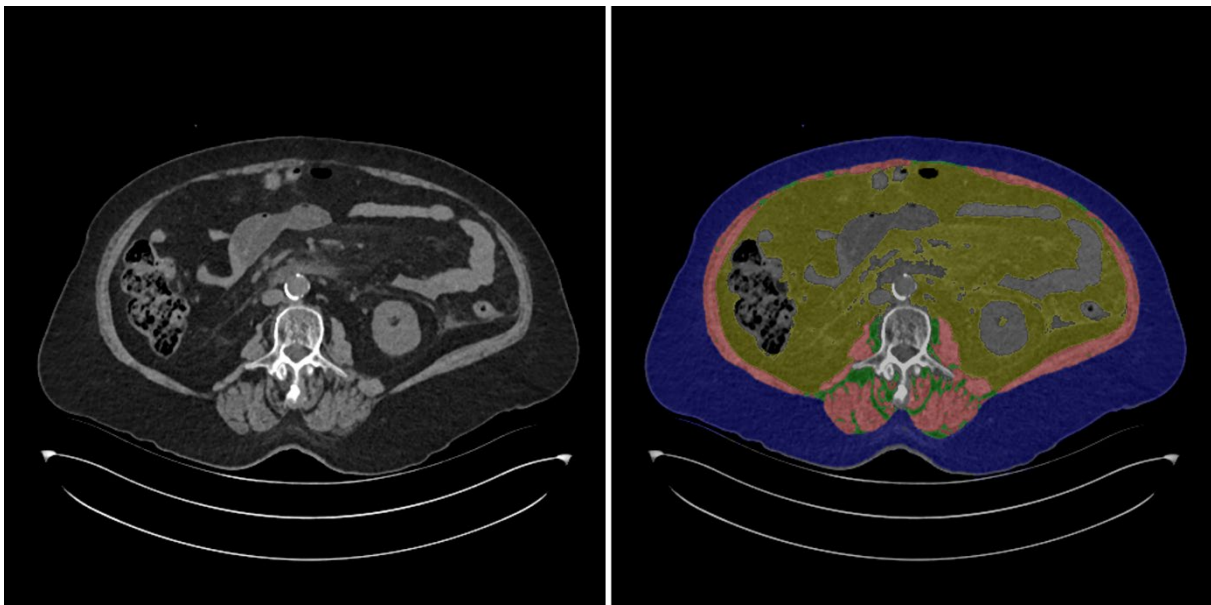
Repräsentative Beispiele für abdominale CT-Scans mit Segmentierung der Skelettmuskulatur: intramuskuläres Fett Gewebe (grün), viszerales Fettgewebe (gelb), subkutan Fettgewebe (blau), Skelettmuskel (rot). Diese Patientin hatte ein SMA von 98,1 cm<sup>2</sup>, ein SMI von 37,4 kg/cm<sup>2</sup>, ein VAT von 314,2 cm<sup>2</sup> und ein VSR von 0,91.
